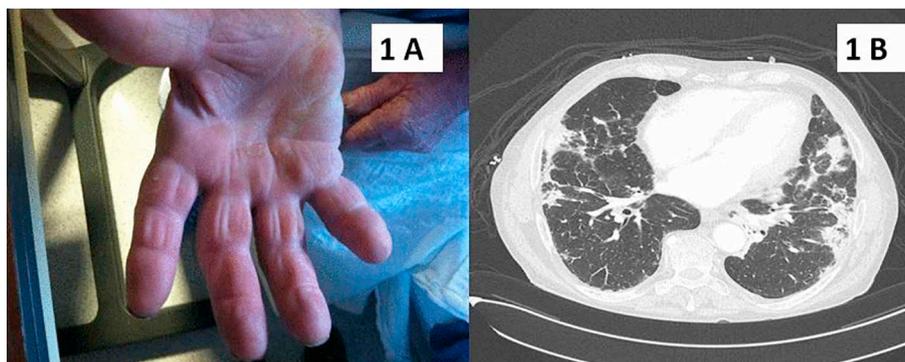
A: Mechanic's hands, the cracking and/or fissuring of the lateral and palmar aspects. B: CT Chest demonstrated small consolidations with peribronchovascular and peripheral subpleural and non-subpleural distribution, some with air bronchogram, and perilobular opacities.
